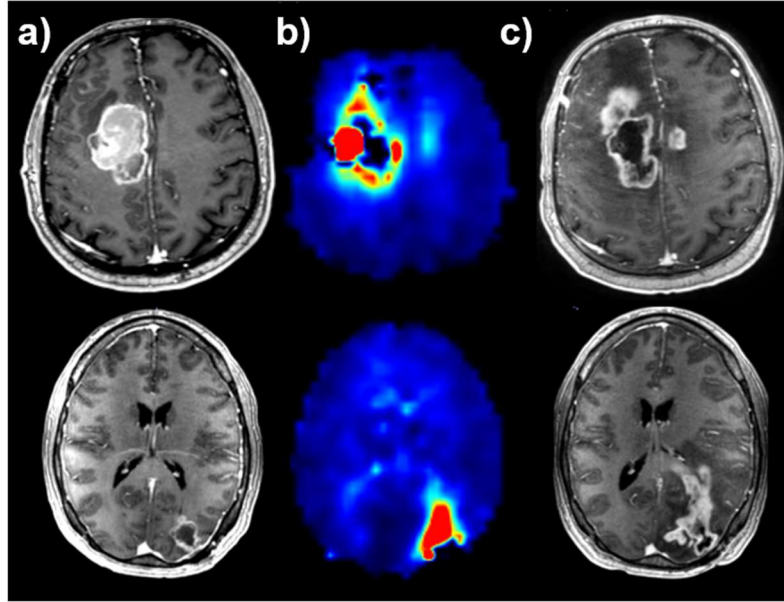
The Cho/NAA ratio can identify occult regions of GBM infiltration. Two cases are shown; (a) CE-T1w MRI taken pre-RT reveals enhancing tumor only, while (b) concurrent sMRI reveals elevated Cho/NAA abnormalities beyond enhancing lesions; (c) a CE-T1w MRI taken 4 weeks post-RT reveals tumor growth along both sMRI abnormalities. Adapted from Cordova et. al., Neuro-Oncology (2016).
